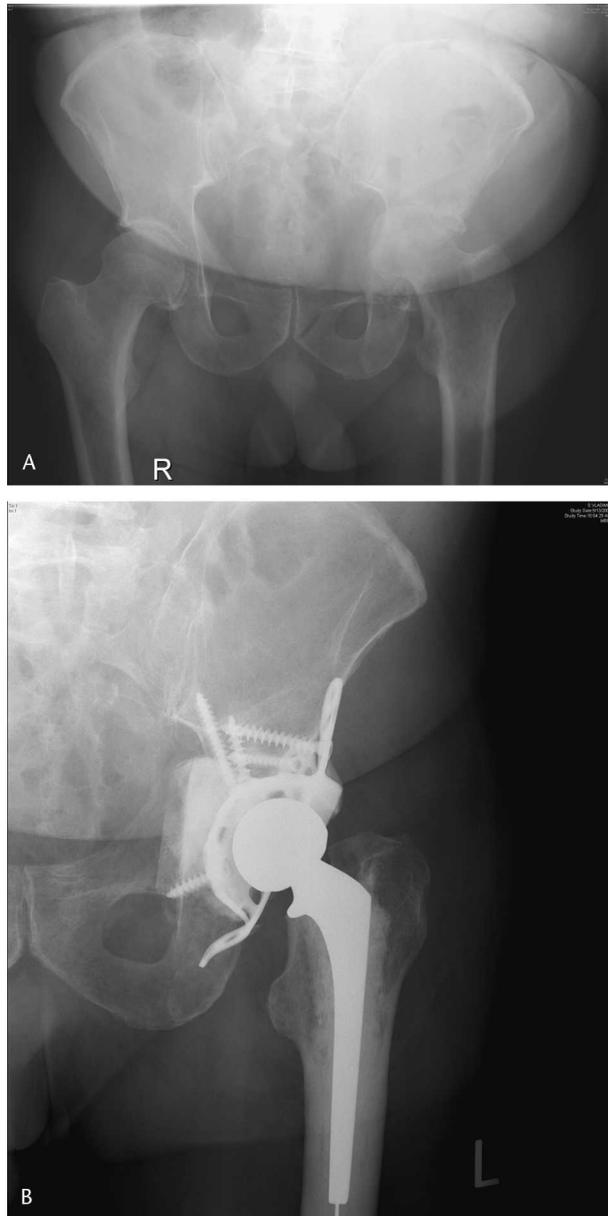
A 71-year-old male patient with multiple myeloma had severe left hip pain and was unable to bear weight on the left side. (A) An anteroposterior (AP) radiograph of the pelvis shows medial wall deficiency and protrusion of the left femoral head into the pelvis. Anterior column disease is also present. (B) The postoperative AP radiograph of the pelvis shows hip reconstruction with an antiprotrusio cage, cementation, and medial wall bone grafting. The femur is reconstructed with a standard cemented prosthesis.
